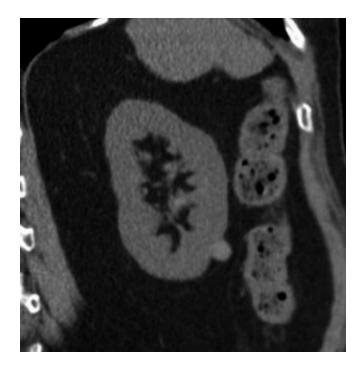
Incidental detection of a 12 mm hyperdense exophytic renal lesion with homogeneous density of 67 HU on non-enhanced CT. After intravenous contrast injection, the density was unchanged. The finding is characteristic for cyst with high-protein content (hemorrhagic cyst)
